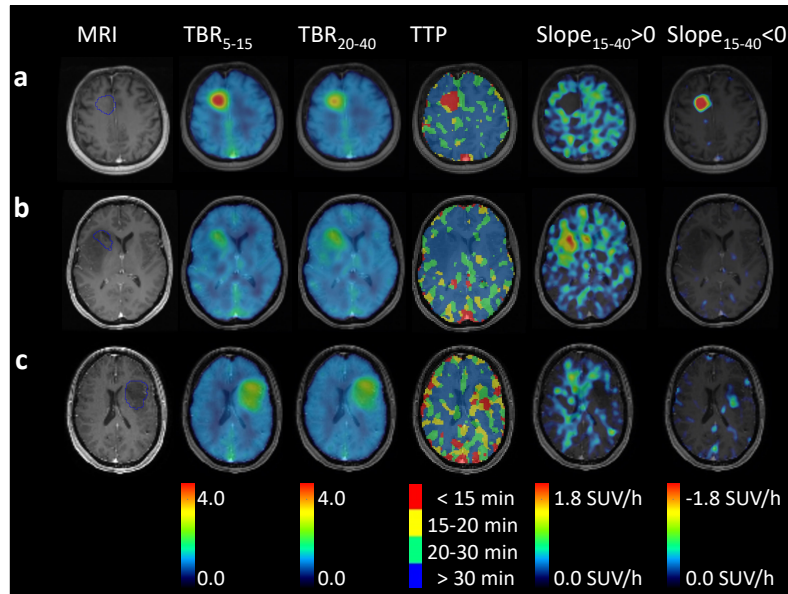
Heuristic parameter maps as applied for PVH-based analysis (chapter 5). Dynamic PET data were smoothed frame-wise with a spatial Gaussian filter (10 mm FWHM) before parameter estimation. From left to right: CE MRI,  $TBR_{5-15}$ ,  $TBR_{20-40}$ , TTP, positive, and negative  $Slope_{15-40}$ . a Typical *IDH*-wt HGG, b typical *IDH*-mut LGG, and c exemplary *IDH*-mut codel LGG glioma with heterogeneous parameter distributions, where the hottest volume in static TBR images did not co-localise with the hot-spots in the TTP map and in the image with negative  $Slope_{15-40}$ .
